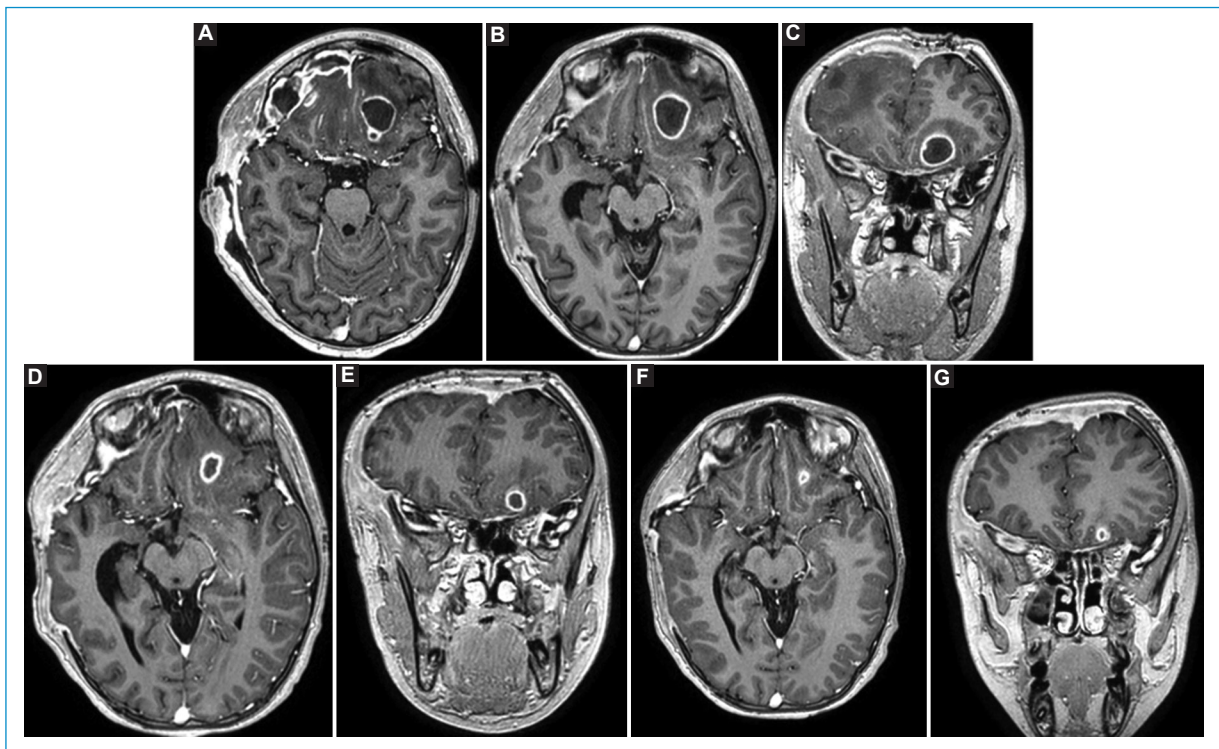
Subdural empyema complicated by intraparenchymal abscess in an 11-year-old girl (case 2). (A) axial T1 MRI with gadolinium; (B, C) axial and coronal T1 MRI on the ninth day of chloramphenicol (total of two days of oral therapy); (D, E) axial and coronal T1 MRI on day 12 of levofloxacin (total of 14 days of oral therapy); (F, G) axial and coronal T1 MRI, two weeks after completing the antibiotic regimen, showing regression of the intraparenchymal abscess.
